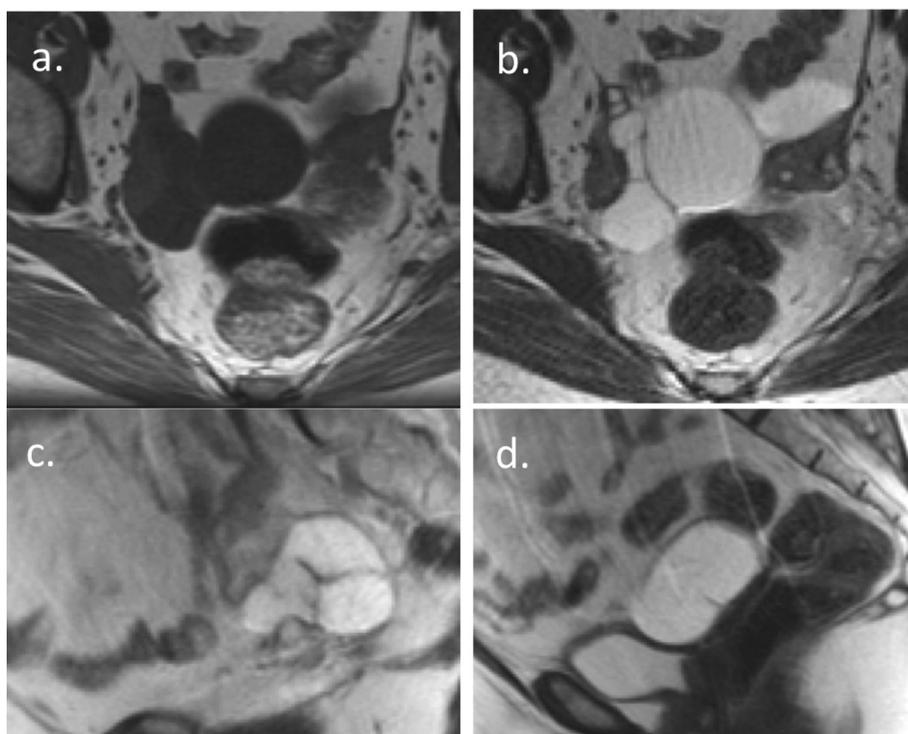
Bilateral hydrosalpinges in a 54 year-old female with history of ovarian-sparing hysterectomy. (a) T1-weighted axial (b) T2-weighted axial (c) T2-weighted right paramedian sagittal and (d) left paramedian sagittal images reveal bilateral tubular cystic structures adjacent to the ipsilateral ovaries.
